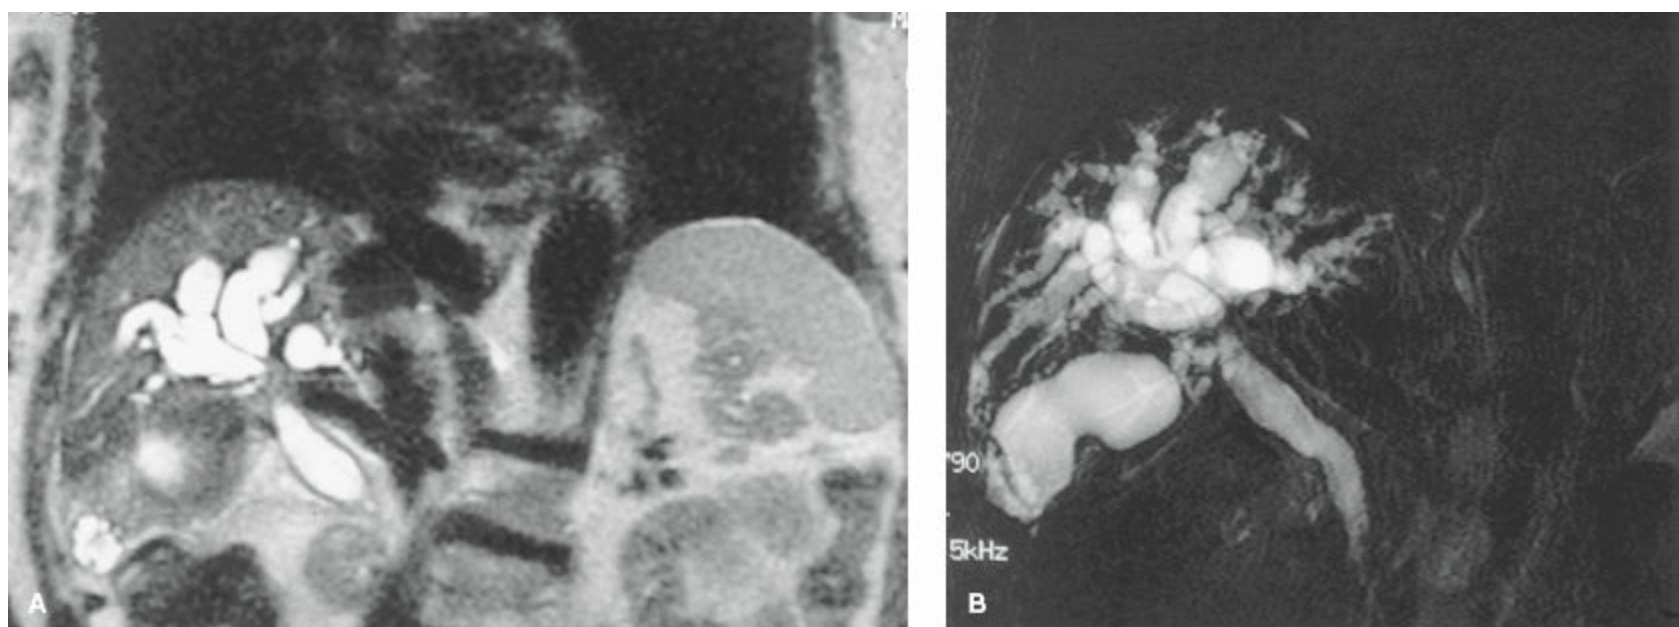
Coronal (A) magnetic resonance imaging and magnetic resonance cholangiopancreatography (B) in a patient with hilar cholangiocarcinoma, demonstrating dilated intrahepatic ducts narrowing at the area of obstruction.
